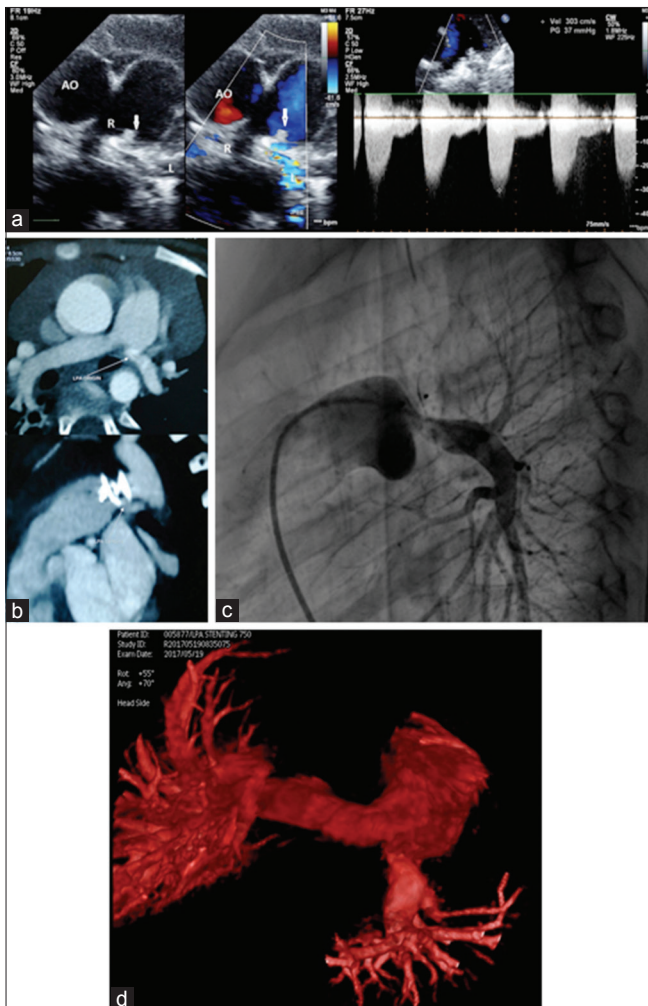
(a) Two-dimensional echocardiography and color Doppler-Amplatzer Ductal Occluder II device *in situ* with left pulmonary artery stenosis. (b) Computed tomography scan shows Amplatzer Ductal Occluder II device impinging on left pulmonary artery causing severe origin stenosis. (c) Fluoroscopic image showing left pulmonary artery origin stenosis. (d) Three-dimensional rotational angiography showing left pulmonary artery origin stenosis
